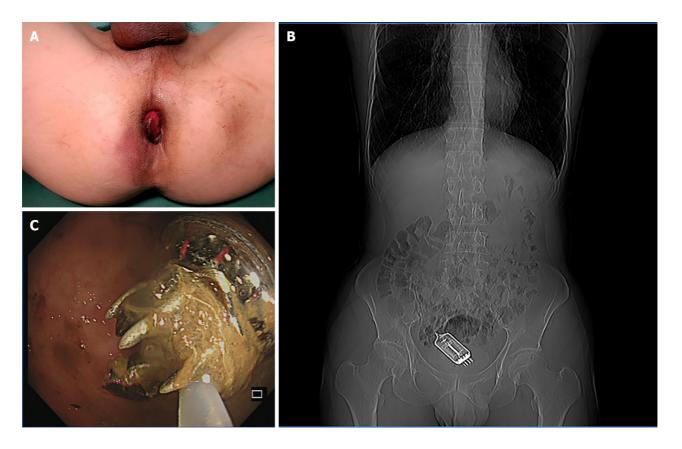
Computed tomography localization of the intestinal foreign body before surgery. A: The patient had anal opening edema, acute prolapsed internal anal hemorrhoids, and surface congestion and erosion prior to surgery; B: Preoperatively, the foreign body was located at the junction of the rectum and sigmoid colon by computed tomography scanning; C: During preoperative colonoscopy, a foreign body was found at the junction of the rectum and sigmoid colon, with the tail end wrapped in intestinal secretions.
